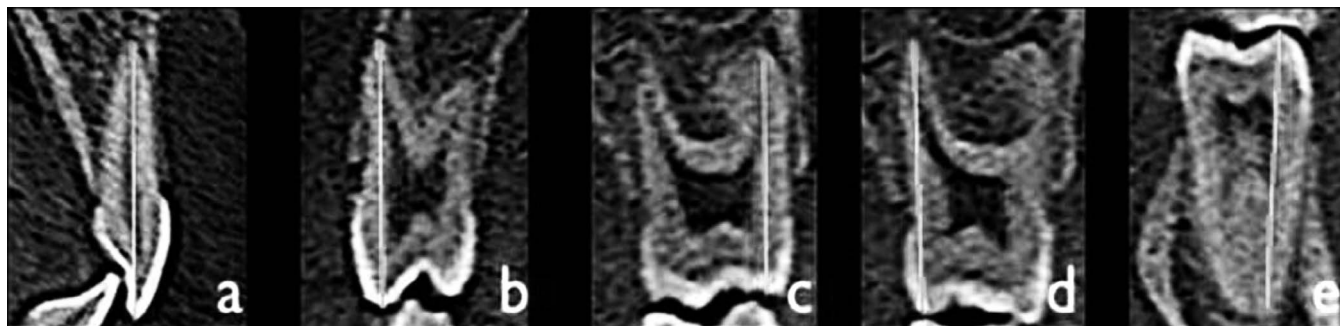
(a) CBCT sagittal view of single-rooted tooth. (b) Coronal view of two-rooted maxillary premolar. (c) Vestibular root of molar. (d) Lingual root of molar. (e) Mesial root of mandibular molar. Line = vertical dental axis (VDA).
